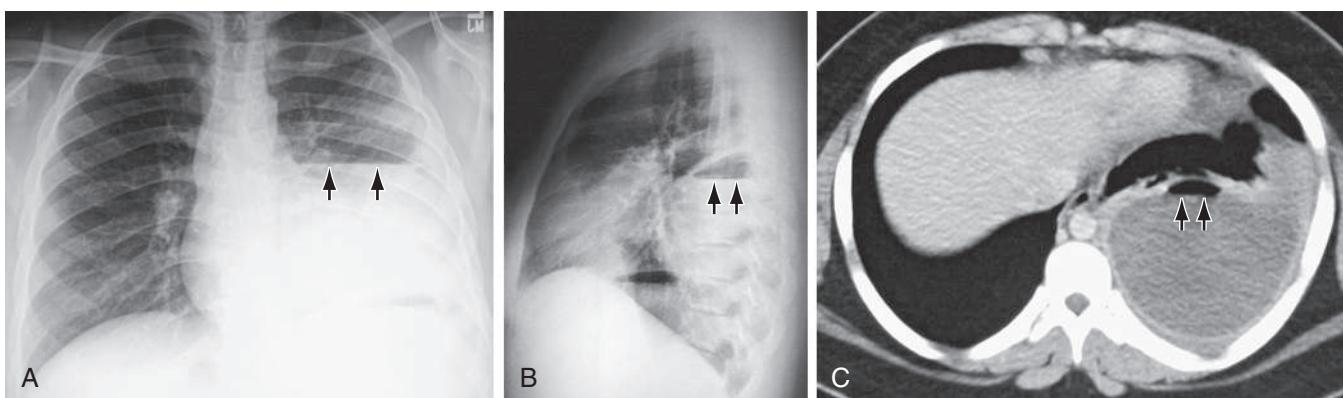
Loculated hydropneumothorax. Frontal (A) and lateral (B) chest radiographs show loculated hydropneumothorax that complicated pneumonia in a 14-yr-old child. Arrows point to the horizontal air-fluid level at the interface between the intrapleural effusion and air. C, Thoracic CT scan helps to localize the loculated hydropneumothorax, with its air-fluid level (arrows).
